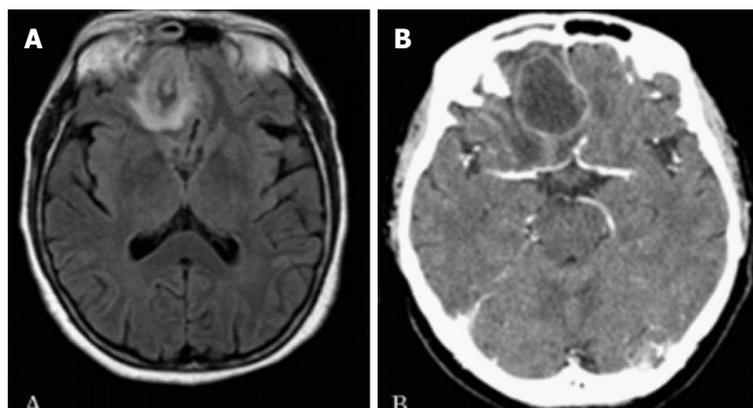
Preoperative images. A: Magnetic resonance imaging with gadolinium showing right frontobasal brain abscess and a second mass occupying the right orbit; B: Contrast-enhanced computed tomography scan.
